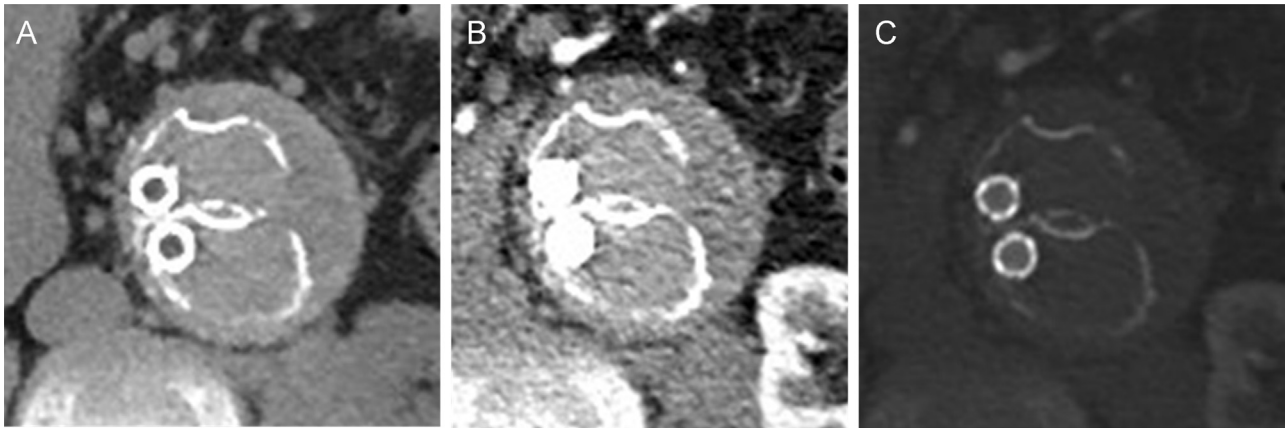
Axial computed tomography images showing artefact from the cobalt-chromium stents. (A) Unenhanced, (B) arterial phase, and (C) arterial phase with adjustment of window level and width.
